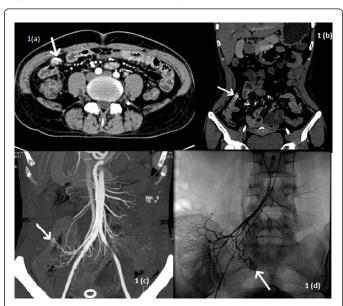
CT angiography and selective arterial angiography for the patient showed the following finding in the distal ileum.
